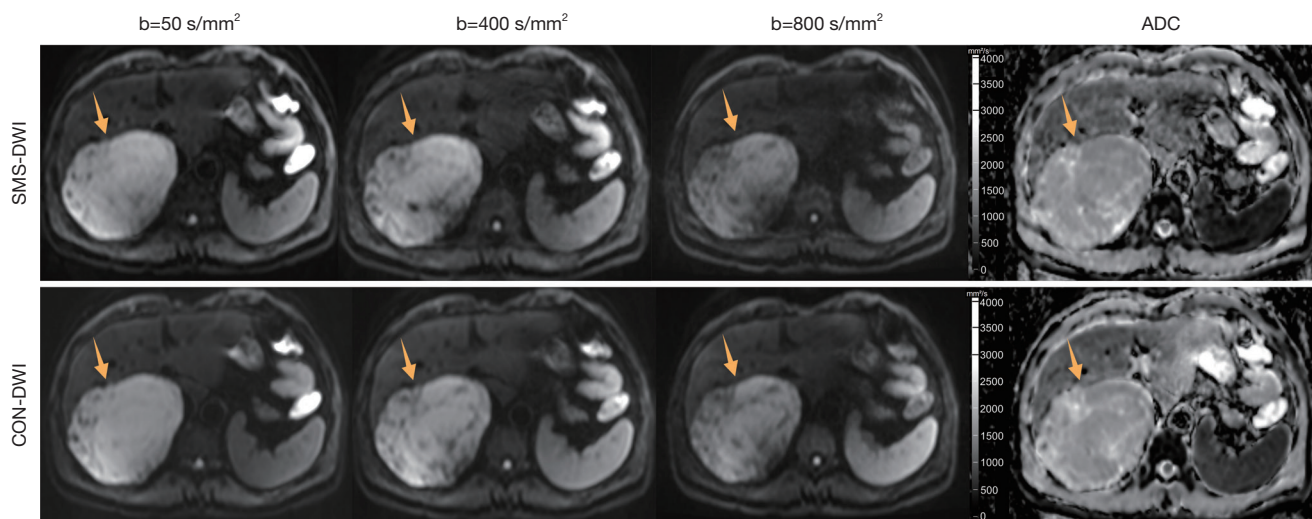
Representative images with SMS-DWI (upper row) and CON-DWI (lower row) of a 59-year-old male patient with pathologically confirmed hepatic cavernous hemangioma. Diffusion-weighted trace images with three different b-values ($b=50$, $b=400$, $b=800$ s/mm²) and the corresponding ADC maps are shown, with the arrows pointing to the lesion. The average ADC measurements were 1.76×10^{-3} mm²/s in SMS-DWI and 1.81×10^{-3} mm²/s in CON-DWI. SMS, simultaneous multislice; DWI, diffusion-weighted imaging; ADC, apparent diffusion coefficient; CON, conventional.
